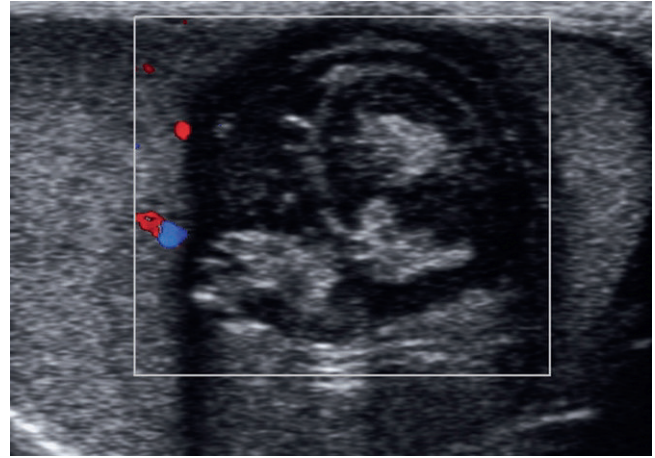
The longitudinal image of the testis shows that there is no color Doppler flow in the lesion.
